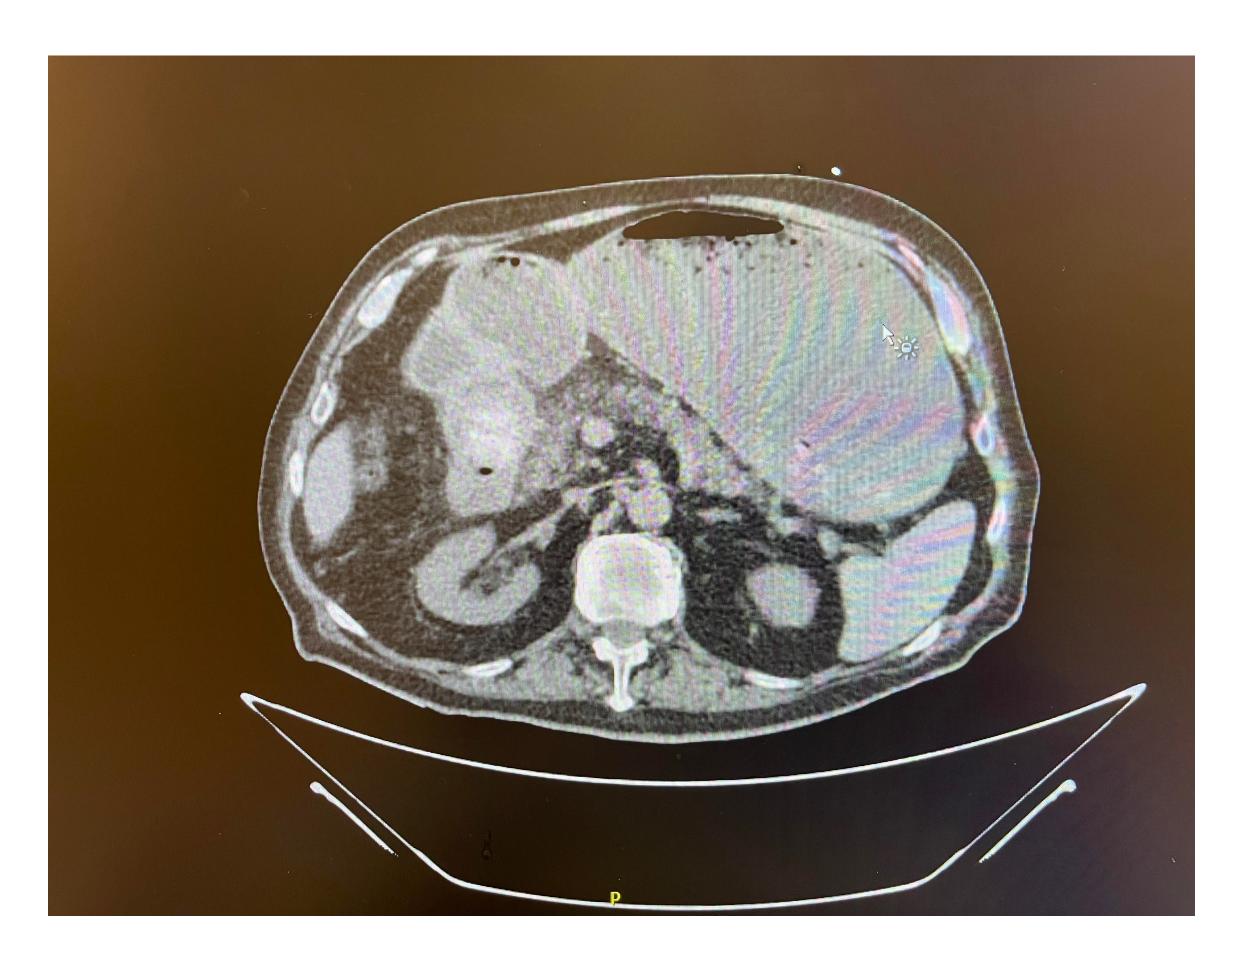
Transaxial contrast-enhanced computed tomography.
